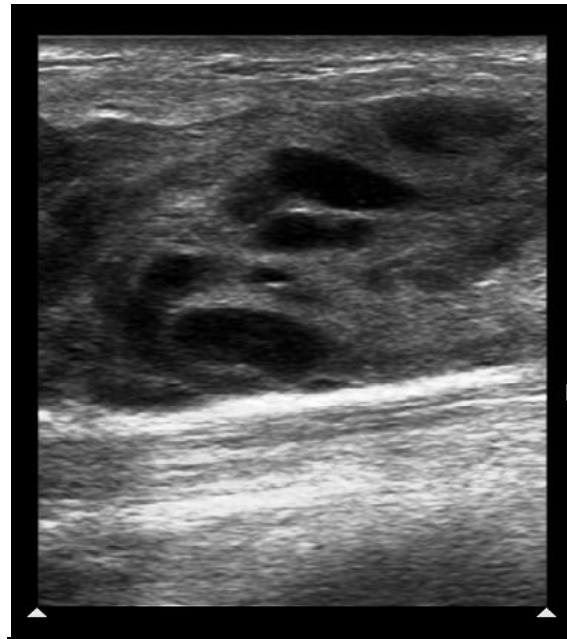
Ultrasound right breast upper outer quadrant showing multiple well-defined hyperechoic and hypoechoic lesions involving all the four quadrants of breast suggestive of numerous enlarged nodes showing central necrosis.
